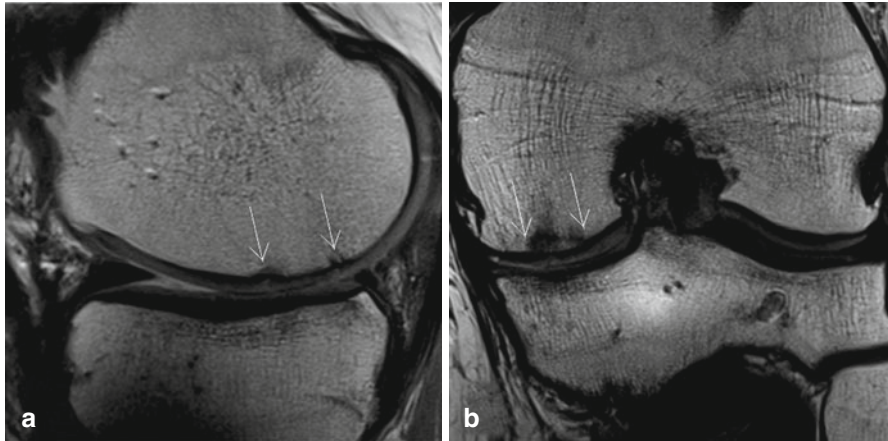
Magnetic resonance images in sagittal (a) and coronal plane (b) of a representative patient 12 months after focal defect repair of the medial femoral condyle using processed allograft (hedgehog). Please note that the patient does not correspond with the pictures shown in Fig. 18.6
